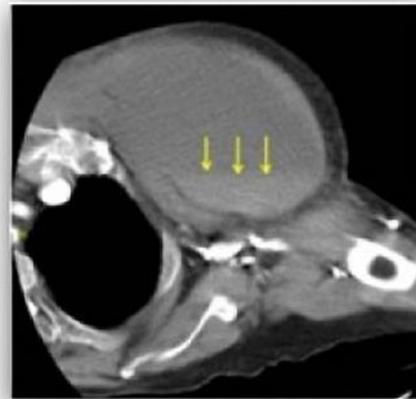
Hematoma in the left breast at thoracic computed tomography
